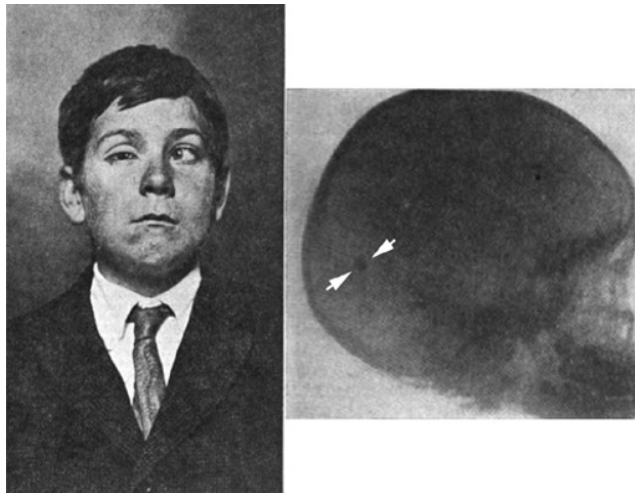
Photograph of a boy with a left abducent nerve palsy (left image) due to a bullet located in his brain, as shown in the 1914 radiographic image (right image). He also has ptosis on the right, which is not from the CN VI injury.
